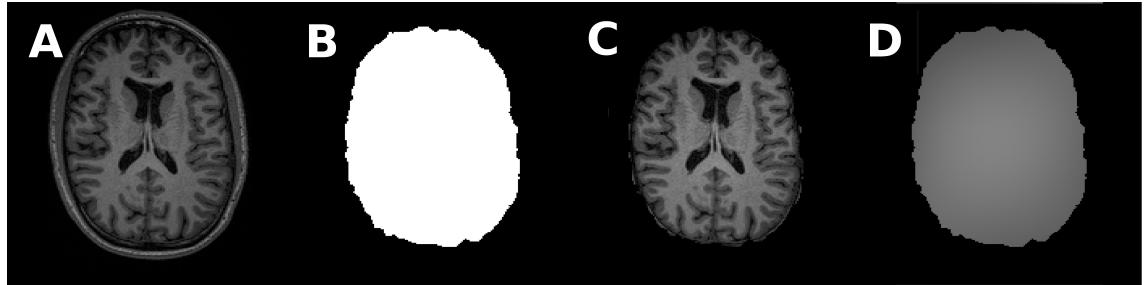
MRI pre-processing steps. A) T1-weighted (T1-w) image sequence. B) Computed brain mask using the BET approach [62] and C) skull stripped T1-w sequence . D) Estimated T1-w bias-field using the N3 method proposed by [61].
